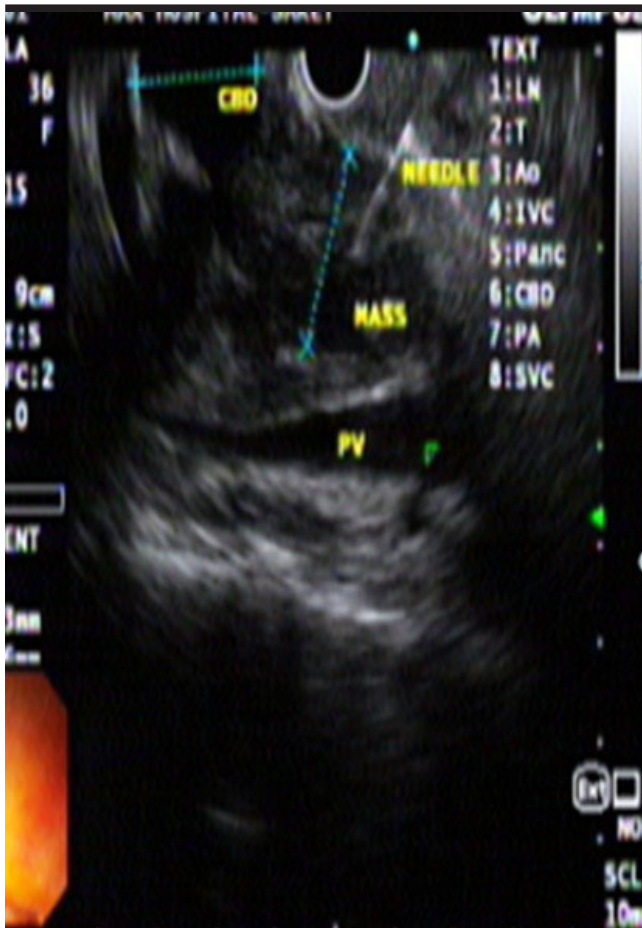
Shows fine needle aspiration of heteroechoic mass lesion of common bile duct on linear array endoscopic ultrasound
